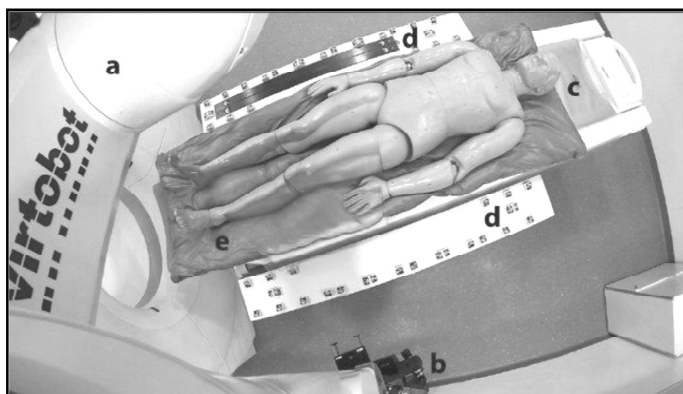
Setting for surface documentation. a: Virtobot; b: mounted optical 3D surface scanner; c: CT-table; d: attached side boards with integrated markers and scale bars; e: deceased placed on a vacuum mattress.
